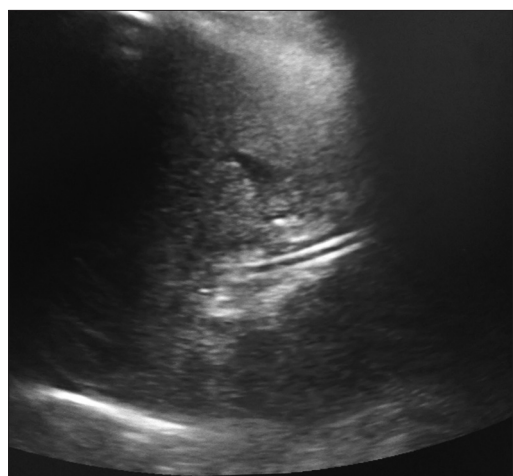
External biliary catheter visualization by ultrasound as parallel echogenic line
